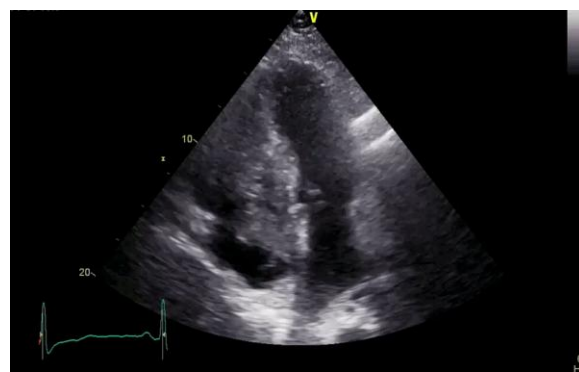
Transthoracic echocardiogram revealed poorly separated from the interventricular septum mass, which completely obliterated the right ventricular cavity and extended into the right atrium. TTE 4-chamber view showing right atrium mass. RA, right atrium; RV, right ventricle; LA, left atrium; LV, left ventricle. White arrow shows intra-ventricular mass.
